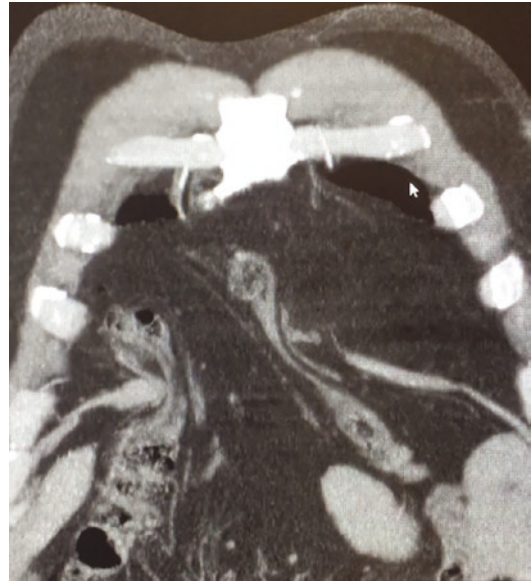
Coronal CT scan of the same patient depicted in Fig. 24.7 revealing large left diaphragmatic defect, with herniating transverse colon into the left posterior thoracic cavity
